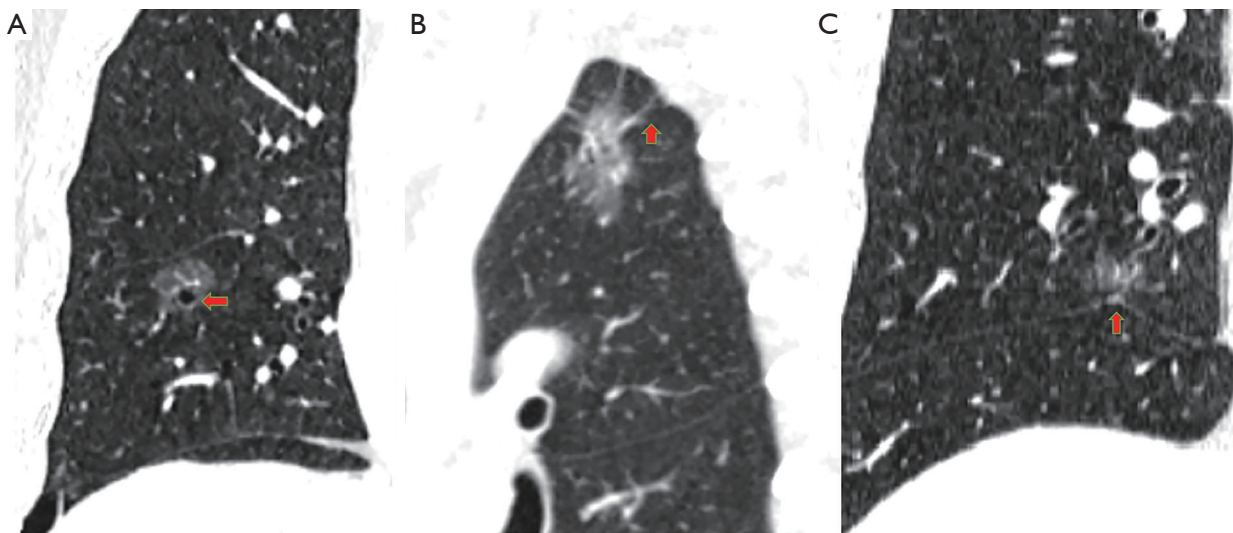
CT signs of pGGN. (A) Bubble-like appearance in the right upper lobe of the lung (red arrow). This appearance is characterized by air-attenuated, vesicle-like lucency within the pGGN. (B) Spiculation in the left upper lobe of the lung (red arrow). Spiculation is defined as the presence of strands extending from the margin of the pGGN into the lung parenchyma without reaching the pleural surface. (C) Pleural indentation along the horizontal fissure (red arrow). Pleural indentation is characterized by linear areas of high attenuation originating from the pGGN, extending peripherally to contact the horizontal fissure. CT, computed tomography; pGGN, pure ground-glass nodule.
